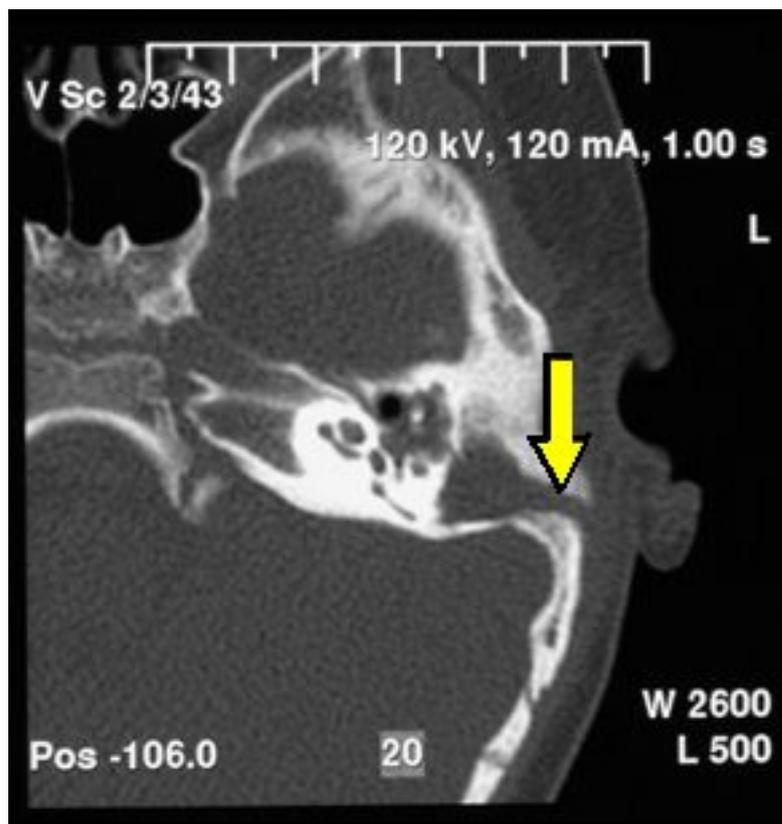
CT scan of Temporal bone. The thick arrow shows the bony discontinuity in the left temporal bone.
